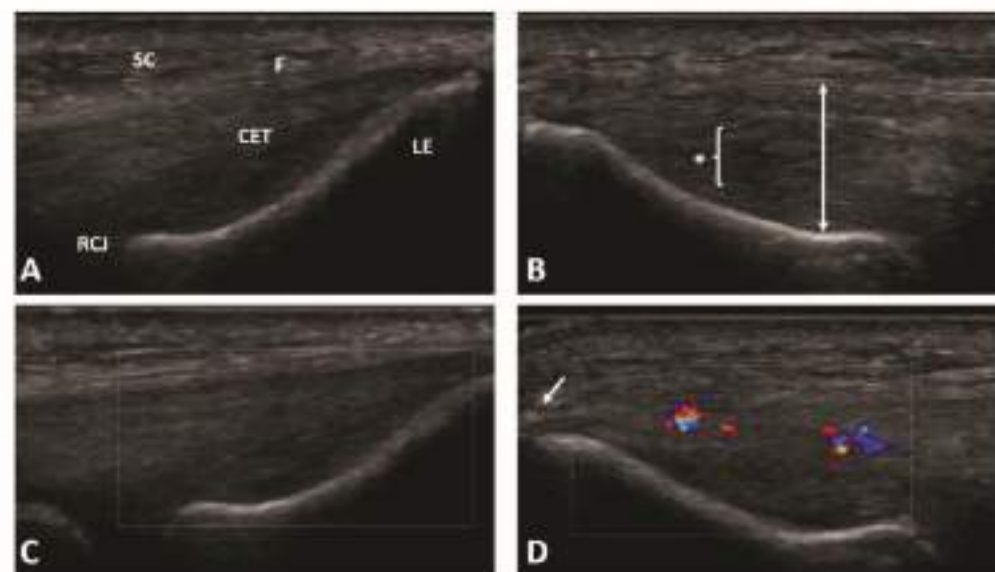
Ultrasound examination of the patient's both elbows for lateral elbow tendinopathy confirmation: (A) healthy lateral epicondyle region of the contralateral elbow; (B) pathological common extensor tendon thickening and region with diffuse hypoechoogenicity typical for lateral elbow tendinopathy; (C) healthy common extensor tendon without activity in color Doppler; (D) neoangiogenesis shown as increased activity in color Doppler in the tendinopathic region. SC—subcutaneous tissue; F—fascia; CET—common extensor tendon; LE—lateral epicondyle; RCJ—radiocapitellar joint; * and bracket—diffuse hypoechoogenic region; two-head arrow—tendon thickness measurement; arrow—enthesophyte.
